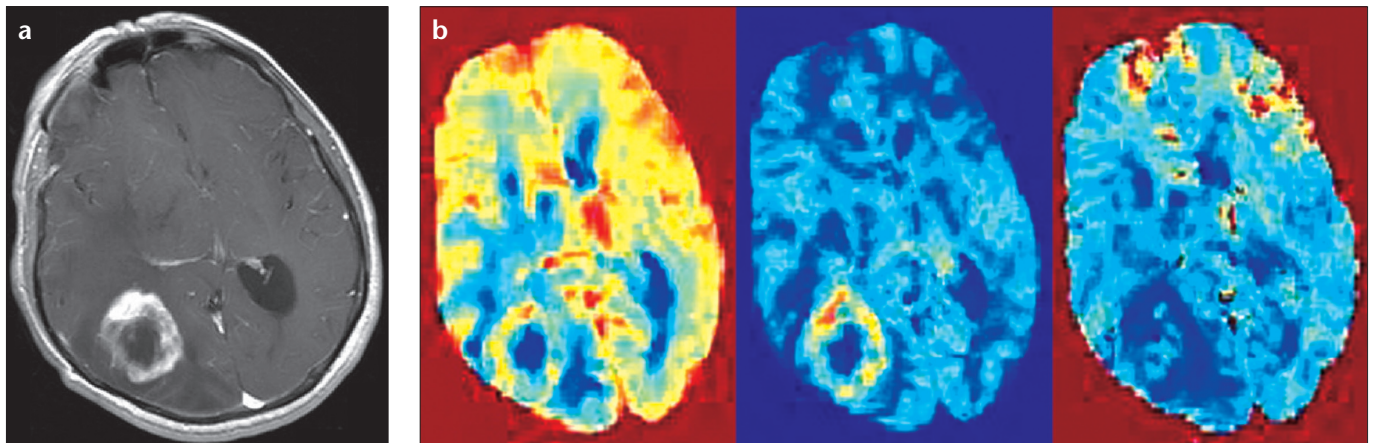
a-c. Patient 18. Transverse post-contrast T1-weighted MR image shows a right parietooccipital metastasis (a). Top row (b) demonstrates the homemade rCBV, rCBF, and MTT maps, and bottom row (c) shows the commercial software maps of a lung metastasis. The mass shows high rCBF, rCBV, and prolonged MTT at the periphery. The results were quite comparable, except that the field definition in MTT was inferior with the homemade software.
